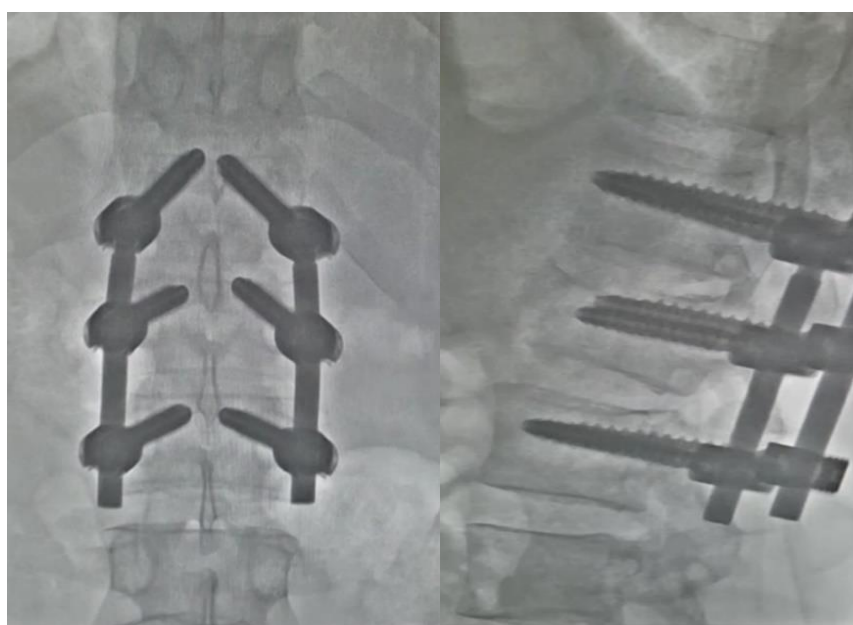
Standard X-ray image showing minimally invasive osteosynthesis with screwing of the displaced body fragment
